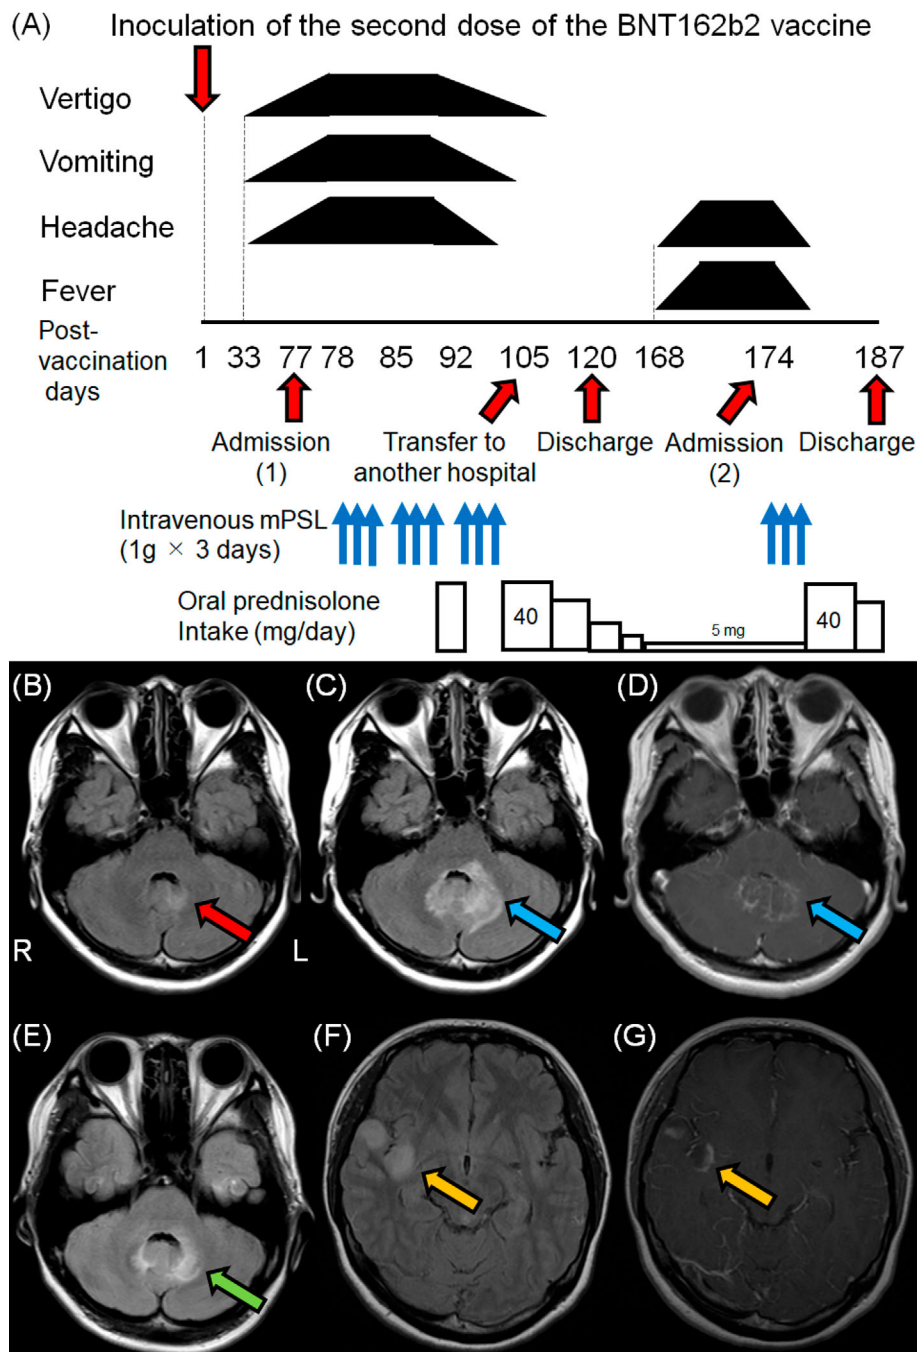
Clinical course and magnetic resonance imaging (MRI) findings of our patient. (A) A healthy 23-year-old woman presented with vertigo, vomiting, and headache from the 33rd day after receiving the second dose of the BNT162b2 vaccine. Her neurological symptoms progressively worsened. After admission, she was treated with 3 courses of intravenous methylprednisolone (IV mPSL) from the 78th day after vaccination, followed by oral prednisolone intake. Her neurological symptoms improved gradually. She was transferred to another hospital for rehabilitation on the 105th day after vaccination. On the 168th day after vaccination, she presented with a fever and headache with relapse lesions on brain MRI. Additional IV mPSL improved her neurological symptoms. (B) Brain MRI on the 57th day after vaccination: fluid-attenuated inversion recovery (FLAIR) image. (C, D) Brain MRI on the 77th day after vaccination: C, FLAIR image; D, T1-gadolinium enhancement image. (E) Brain MRI on the 89th day after vaccination: FLAIR image. (F, G) Brain MRI on the 173th day after vaccination: F, FLAIR image; G, T1-gadolinium enhancement image. mPSL: methylprednisolone
